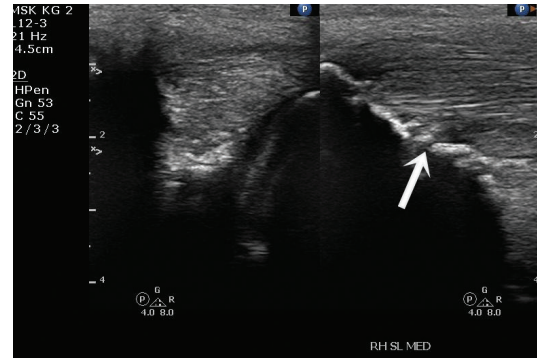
Pre-operative ultrasound of the SBL ligament-bone interface (arrow points toward the darkened site of injury).
